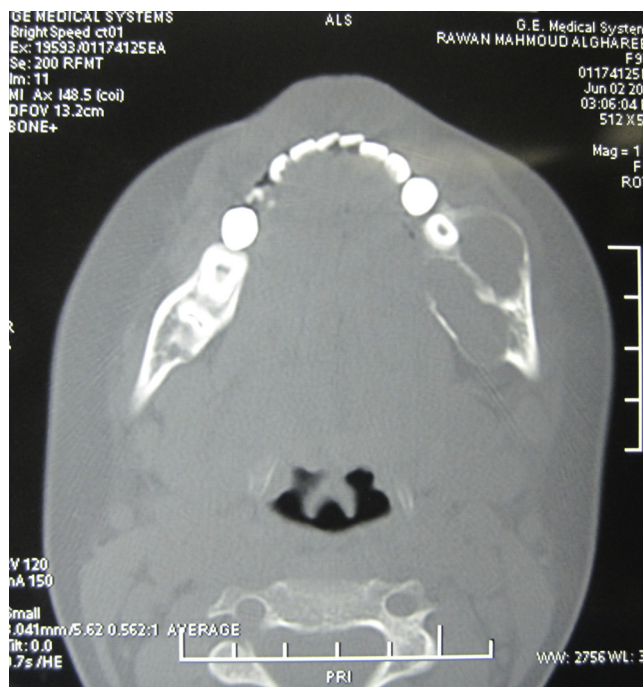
Axial CT cuts showing extensions of lesion buccolingually and the lesion multilocularity.
